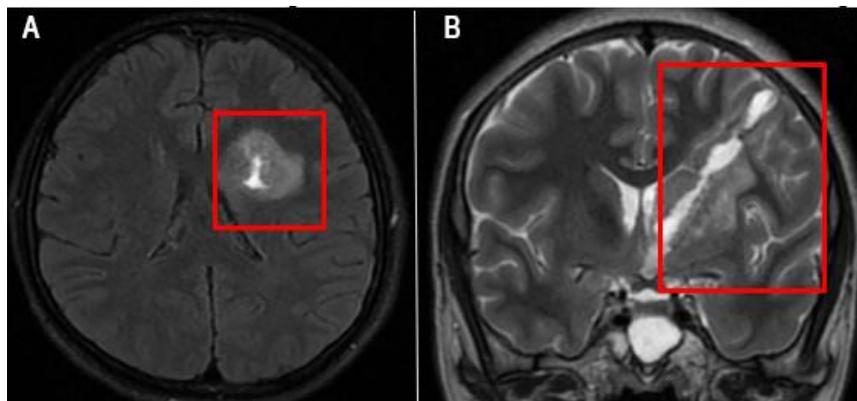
Preoperative brain MRI scans. A) Axial T1-weighted image: visualizes a post-traumatic hemorrhagic focus in the region of the basal ganglia of the left cerebral hemisphere. B) Coronal T2-weighted image: visualizes the trajectory of the traumatic injury
